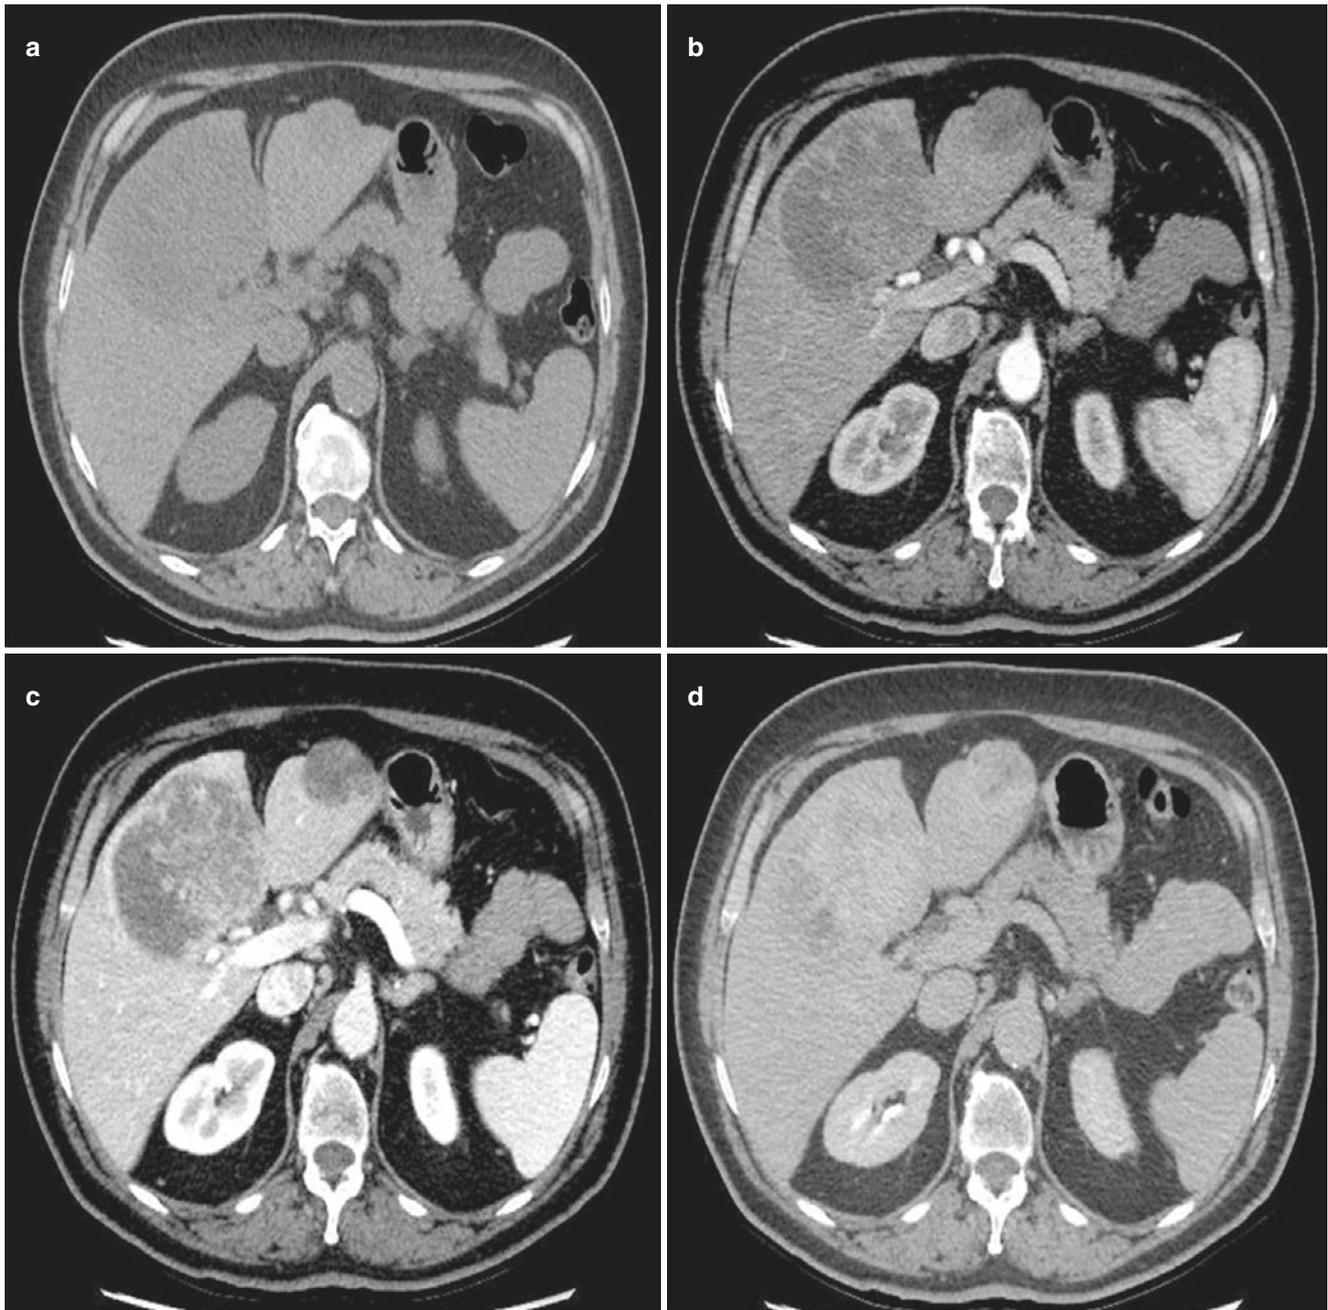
(a–d) Multifocal peripheral mass-forming cholangiocellular carcinoma. Unenhanced CT scan (a) shows a large, heterogeneously hypodense mass with lobulated margins in the IV–V–VIII hepatic segments and another smaller one with analogous CT appearance in the III
